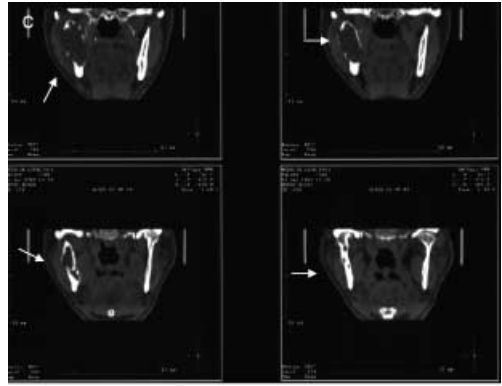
The characteristic computer tomography image (coronal CT) of OKC on predilection location (the angles and vertical branches of the lower jaws). CT images show perforation of OKC in the right mandibula ramus.
